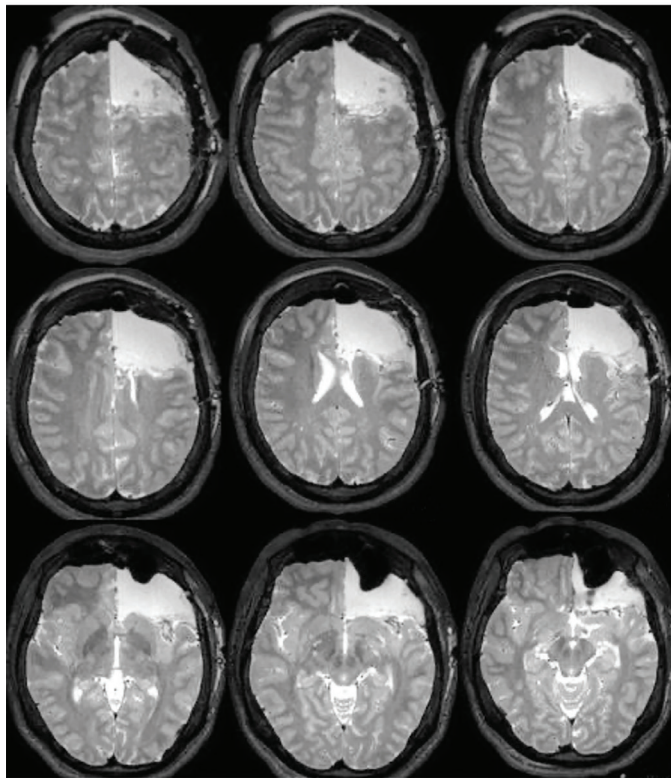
Postoperative MRI (axial T2) after frontal lobectomy
